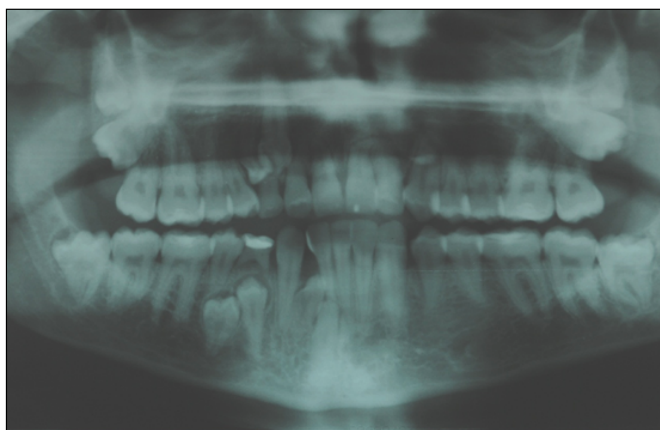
The X-Ray O.P.T. shows the presence of multiple impactions and supernumerary teeth.
